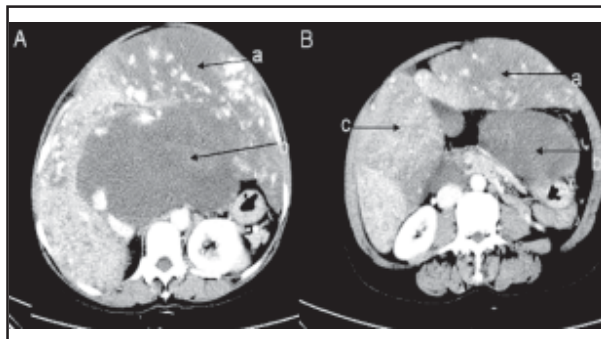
Abdominal CT shows homogenous hypodense lesions with the characteristic of hemangioma in right, left and caudate lobe. The arrows show three giant hemangiomas. a: a giant hemangioma of 20.2*7.3cm in left lobe; b: another giant hemangioma of 17.7*8.5cm in caudate lobe; c: a lesion of 7.8*5.7cm in segment E.
